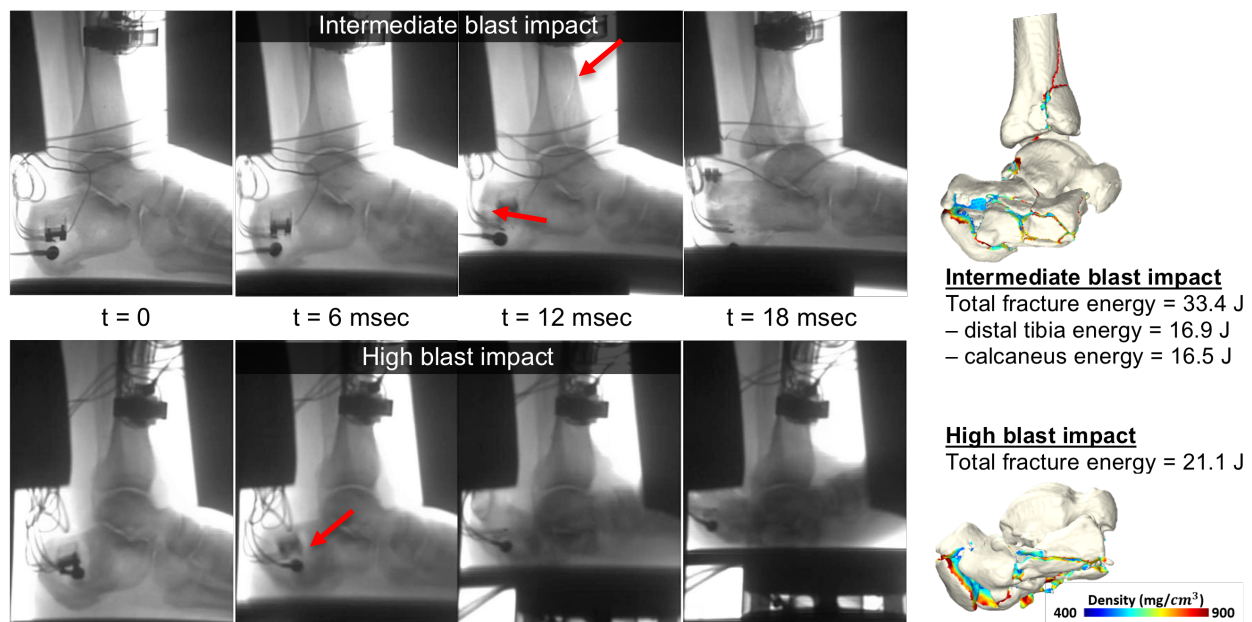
These series of radiographs obtained during impact loading show for the high blast impact (lower row of images) an early fracturing of the calcaneus ($t = 6$ msec, red arrow), while for the intermediate blast impact (top row) a later fracturing of both the distal tibia and the calcaneus ($t = 12$ msec, red arrows). Interestingly, the high blast impact involved less fracture energy liberation than did the intermediate blast.
